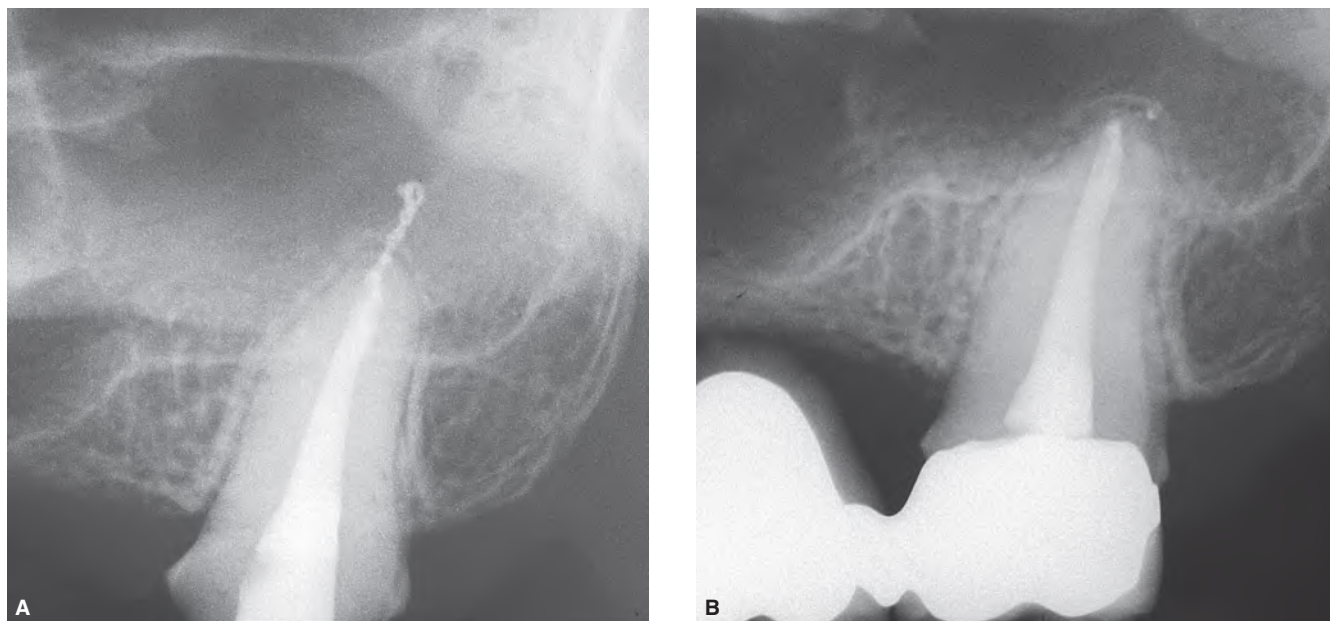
A.* Postoperative radiograph of a maxillary left second molar treated endodontically. Note extruded material beyond the apical foramen. *B.* Radiograph taken eight months later showing the excess material is no longer present.
